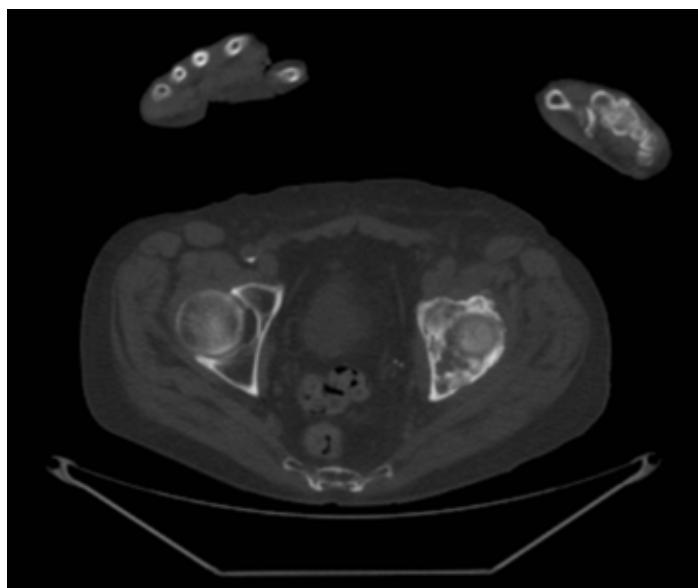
Destructive lesion of the left ilium extending down to the superior aspect of the left acetabulum. CT imaging indicated given the complex anatomy of the pelvis and possible percutaneous palliative treatment options.
